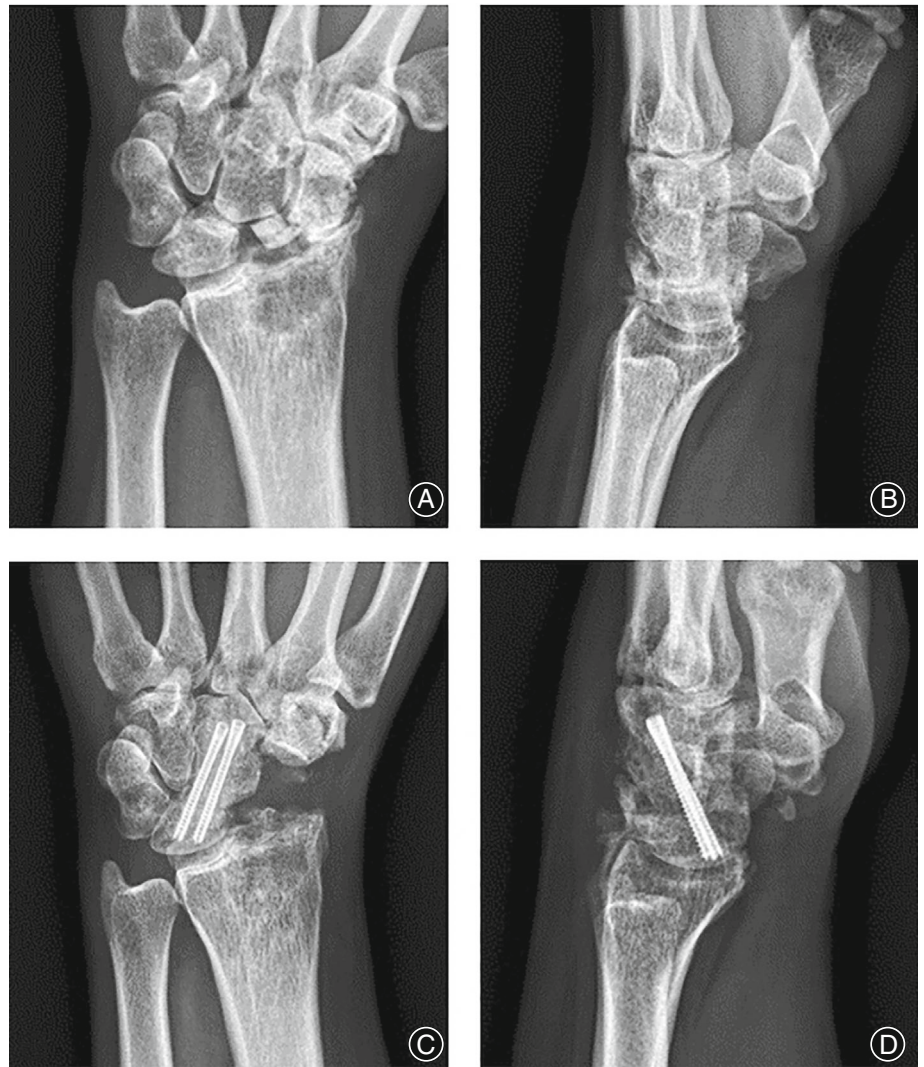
A 39-year-old female. Radiograph showing (A) and (B) stage III SNAC of her left wrist; (C) and (D) 12 months after lateral approach for scaphoid excision and capitulate arthrodesis.
